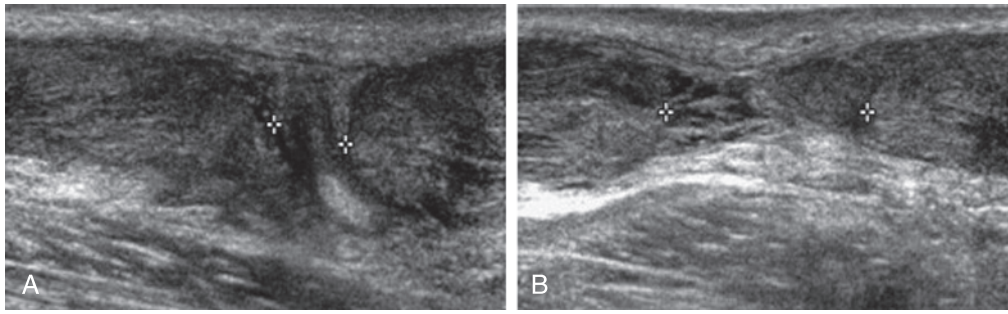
A, Longitudinal ultrasound scan of a ruptured Achilles tendon during plantar flexion shows less than 1 cm of separation between the torn tendon ends. The patient was successfully treated with casting in plantar flexion. B, Same patient with longitudinal scanning in dorsiflexion shows increased separation and better delineation of the complete tendon rupture. (From Fessell DP, Jacobson JA. Ultrasound of the hindfoot and midfoot. *Radiol Clin North Am*. 2008;46(6):1027–1043.)
